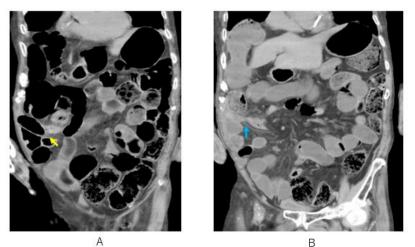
On the onset day, dilated small bowel whose diameter is 3cm or greater and dilated colon are depicted on coronal CT. Note the swollen appendix (yellow arrow) and the occlusive site (blue arrow) which is present, adjacent with appendix.
